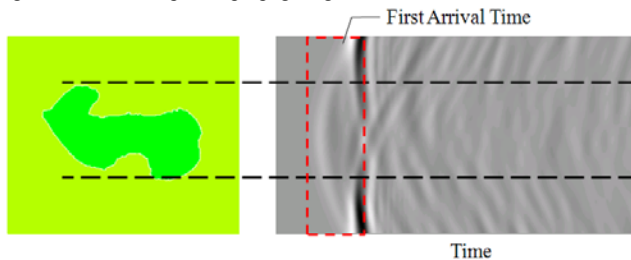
Arriving ultrasound waves in the receiver region.
